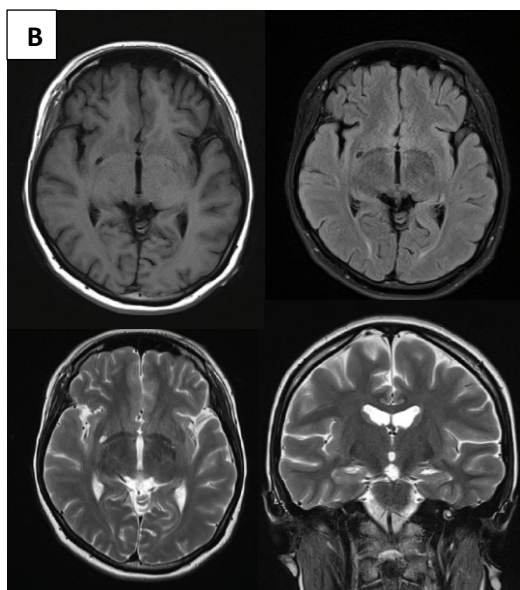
Brain MRI showing pathologic lesion in right basal ganglia, (A) Relapse episode, (B) First attack episode
